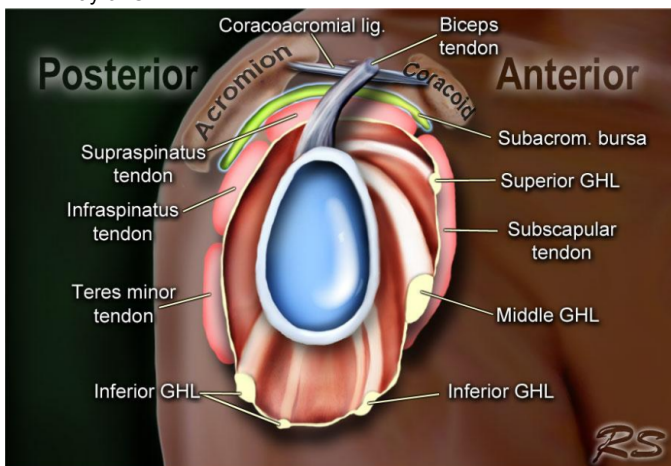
Sagittal Shoulder MRI
